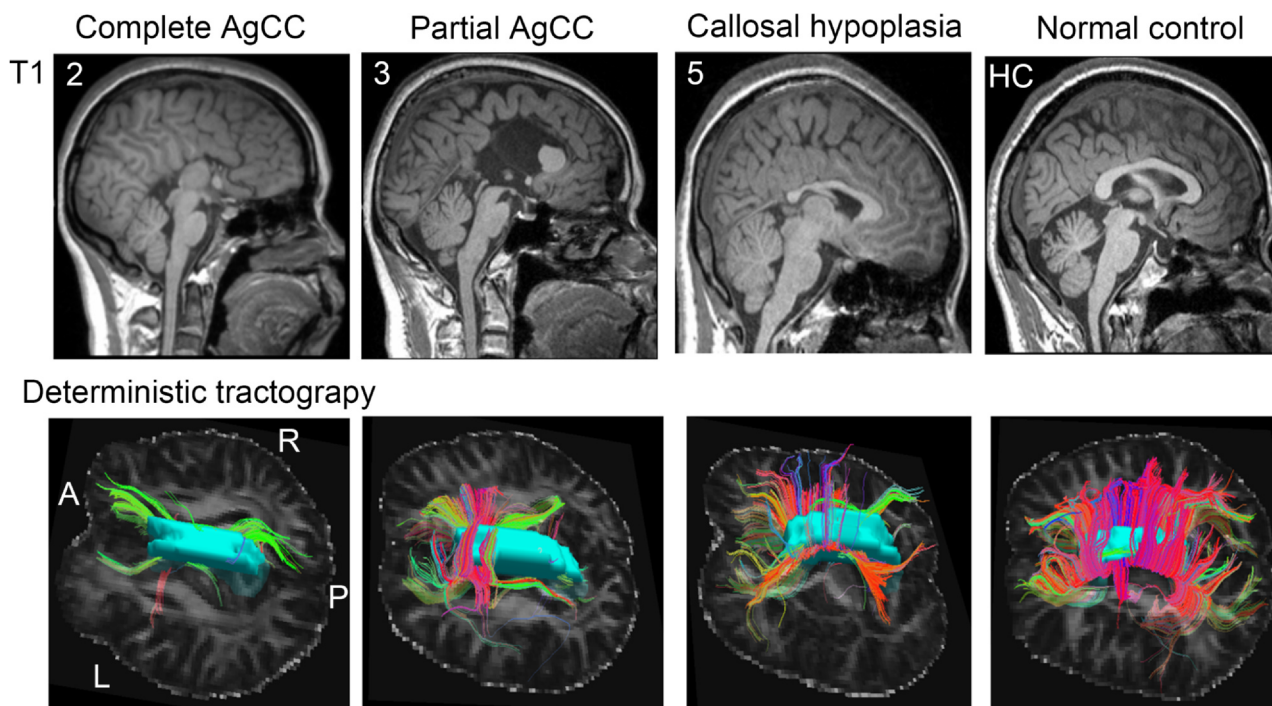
T1-weighted MR images with midline sagittal view and the corresponding deterministic tractography of four representative subjects. Three types of AgCC (the first column is patient no. 2 with complete AgCC, the second column is patient no. 3 with partial AgCC, the third column is patient no. 5 with callosal hypoplasia) and one healthy control (the fourth column) are presented. In the lower panel, an axial slice of the FA image was used as the background. A normal complete corpus callosum (CC) structure is shown by the cyan color. Colored streamlines represent white matter fibers crossing the CC structure. Spatial marks indicate the orientation of the 3D image, anterior (A), posterior (P), left (L), and right (R). (For interpretation of the references to color in this figure legend, the reader is referred to the web version of this article.)
